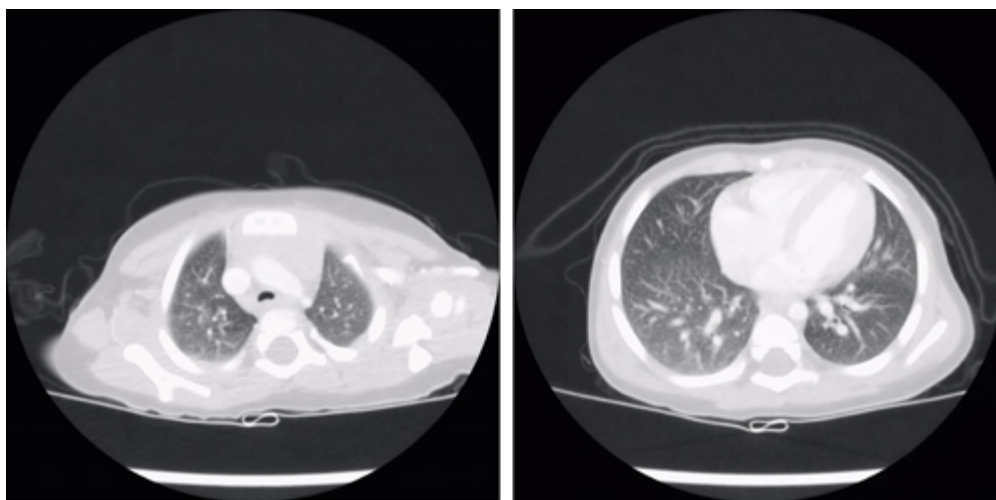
Chest CT images demonstrating mild mosaic attenuation thought to be too limited in extent to explain the clinical features. [↩](#)
